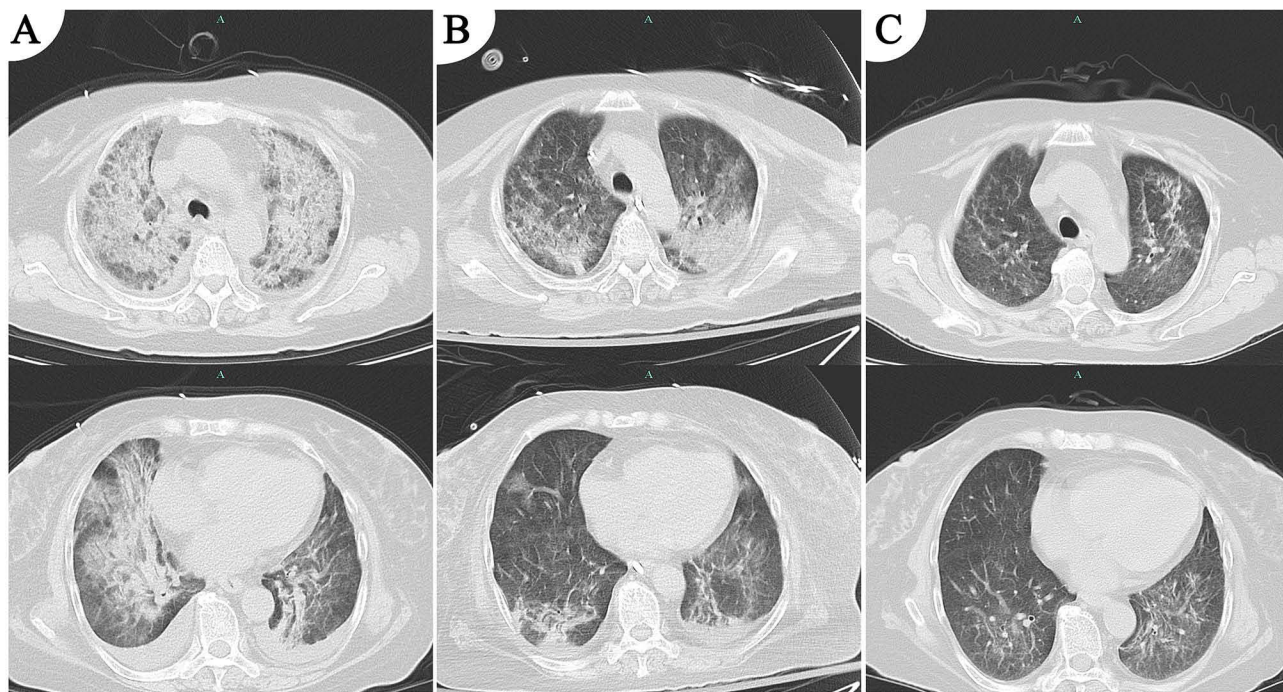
Changes in pulmonary lesions on CT imaging. (A) (Day 1) The initial CT scan indicated extensive inflammation in both lungs, with a possible diagnosis of interstitial pneumonia; pleural effusion was also present. (B) (Day 7) The follow-up CT scan shows a reduction in inflammation in both lungs compared to before, with a reduction in pleural effusion (C) (Day 11) The CT scan after targeted antibiotic and relevant treatments showed a significant reduction in inflammation in both lungs, with pleural effusion was nearly resolved.
